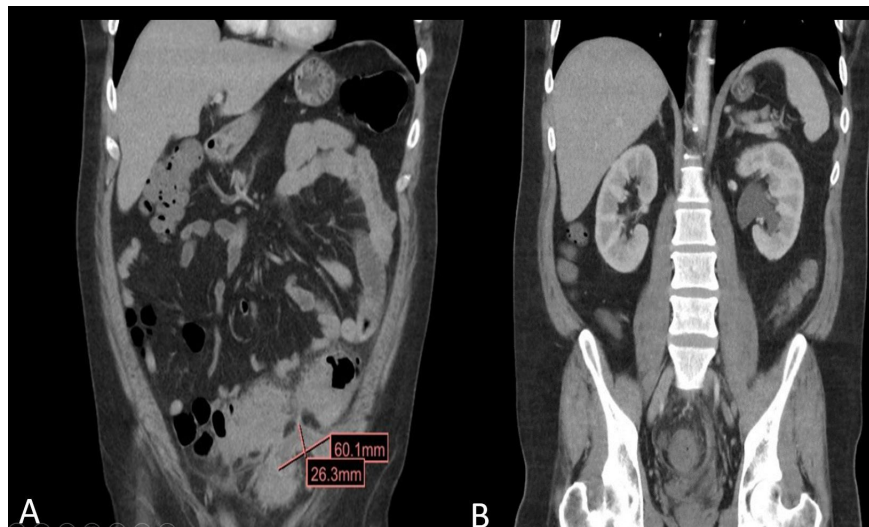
Computed tomography (CT) scan of the abdomen with contrast revealed severe sigmoid diverticulitis and perisigmoid abscess measuring 6 x 2.6 cm (Figure 1a). It further revealed moderate left hydronephrosis with narrowing of the ureter, concerning for external ureteral compression by the diverticular abscess (Figure 1b)
